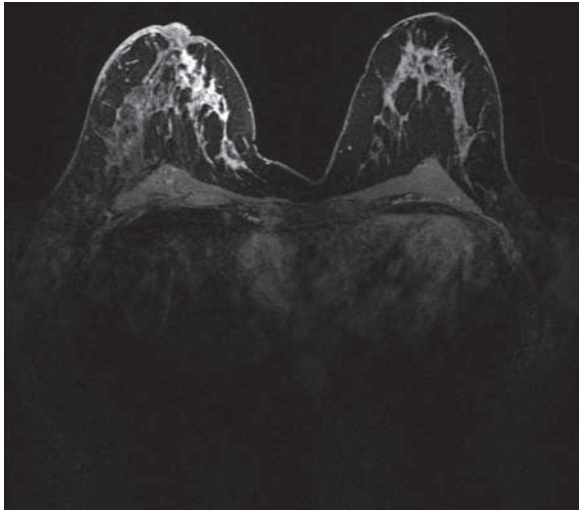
MRI demonstrating mass secondary to DCIS (*left half of figure*)
